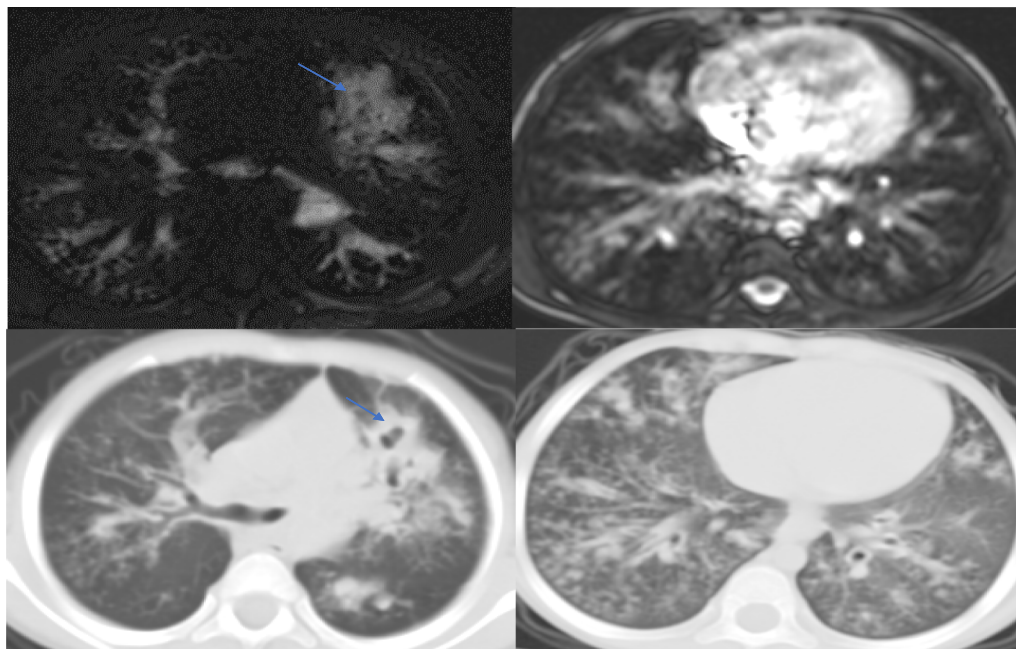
A 5-year-old male, known with cystic fibrosis, MRI T2 TRUFI, and comparable HRCT cuts, shows bilateral score 1 bronchiectasis, score 2 bronchial wall thickening, score 3 generation of bronchi, diffuse centrilobular nodules and tree in bud appearance, and mucoid impaction (arrows), CT score 21, MRI score 17
